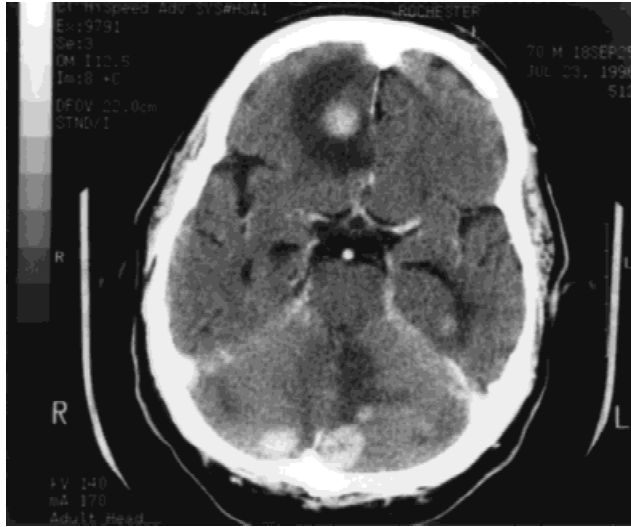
Contrast enhanced CT scan of the head. Multiple enhancing lesions in both hemispheres.
